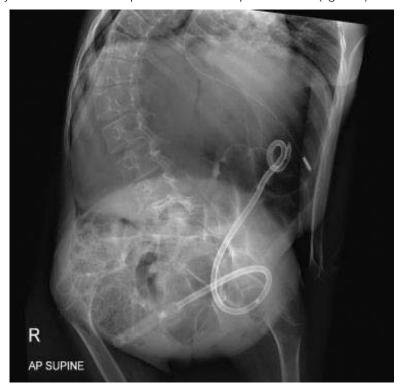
The abdominal X-Ray showing the feeding tube in the stomach and free air in the peritoneal cavity together with the vertebral column and limbs deformities
